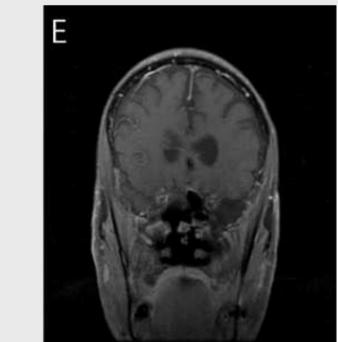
Post-operative MRI With contrast showing complete tumor excision
